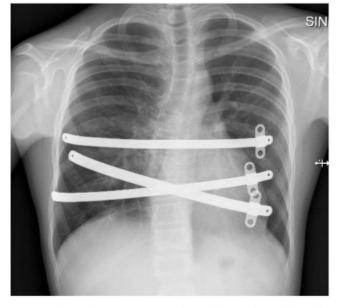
Chest radiograph showing 3 substernal bars and 3 stabilizers after minimally invasive repair of pectus excavatum.
